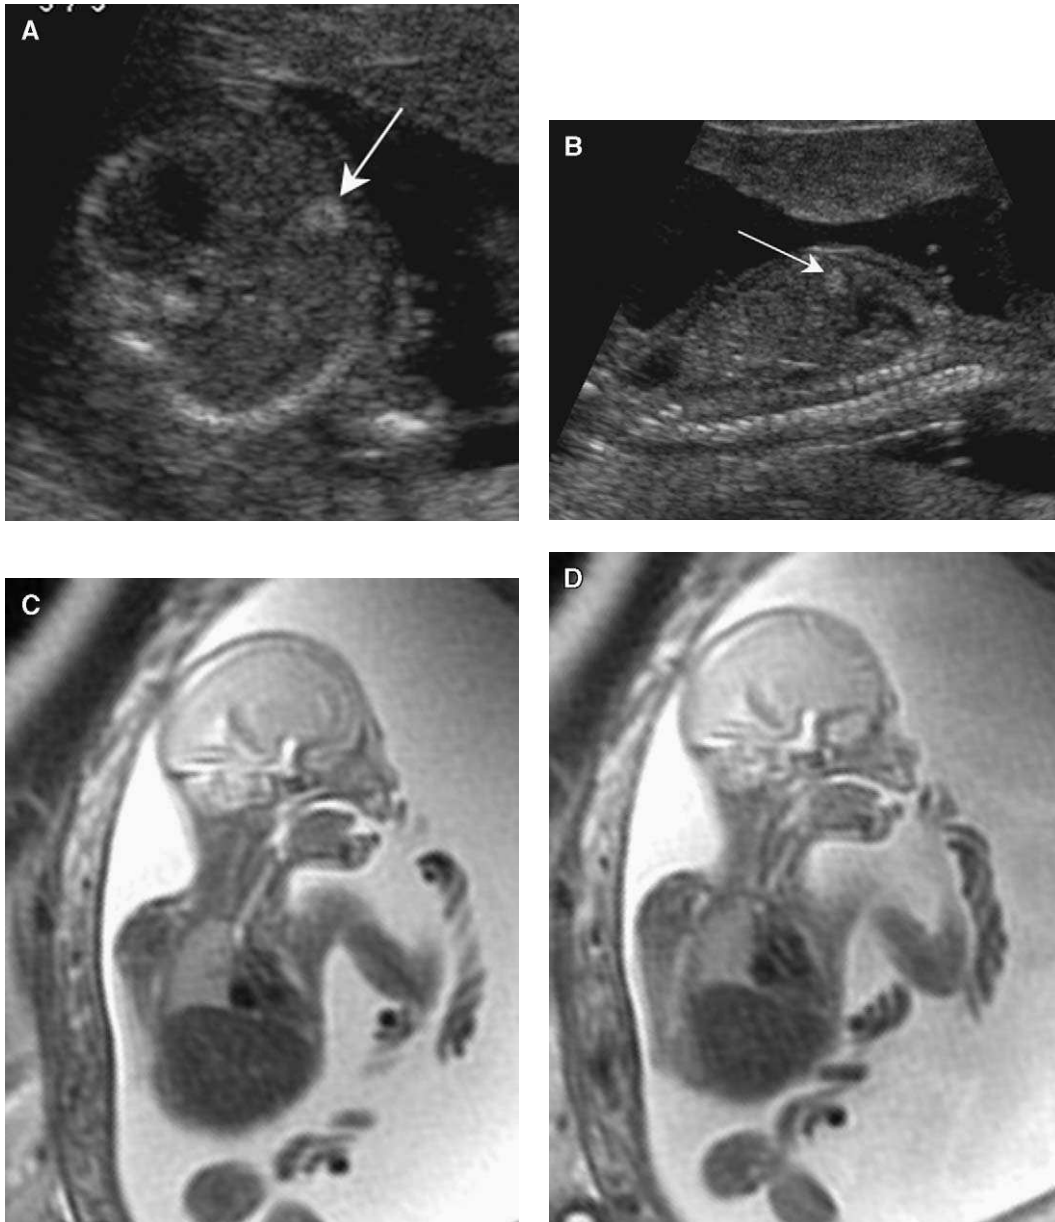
US (A,B) and MR imaging (C,D) in a fetus at 21 weeks' gestation with a small echogenic mass in the liver. The mass is well seen on US (arrows) but is not visualized on MR imaging.
